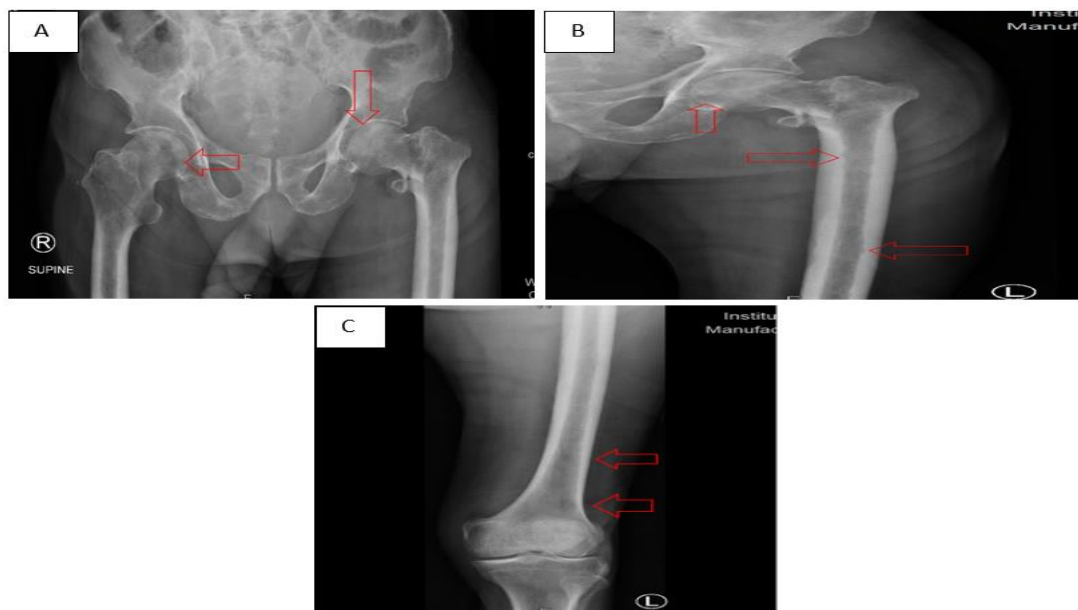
Radiographic imaging of the left femur and pelvis demonstrating metastatic bone disease: (A) AP pelvis view showing a displaced left femoral neck fracture with bilateral proximal femoral lytic lesions; (B) Left femur X-ray revealing lytic lesions in the shaft and sub trochanteric region ;(C) Distal femur X-ray highlighting metaphyseal lytic lesions.
